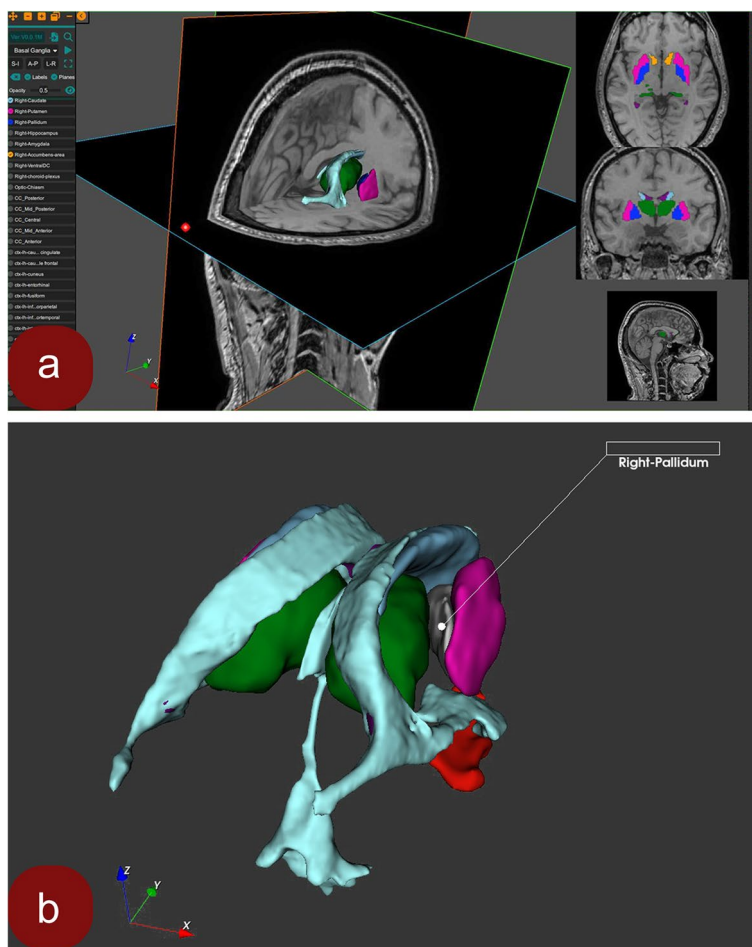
Screenshots from *AnaVu* user interface. a Shows the graphic user interface of *AnaVu*, which consists of 3 main vertical panels. The basal ganglia and the ventricles are visualized in the middle and right panels. Left panel shows the 'buttons' and controls for selecting lessons, structures, modifying opacity, and selecting monoscopic or stereoscopic visualisation modes. Middle panel shows the 3D viewport for 3D image demonstration. Right panel shows the three canonical 2D sections (axial, coronal, and sagittal sections of T1-MRI images) in that order from top to bottom, and the 2D sections of the 3D model (shown in the middle panel) colored correspondingly. These sections are scrollable by cursor. b Shows the right globus pallidus (pallidum) being selected when the label pops up
